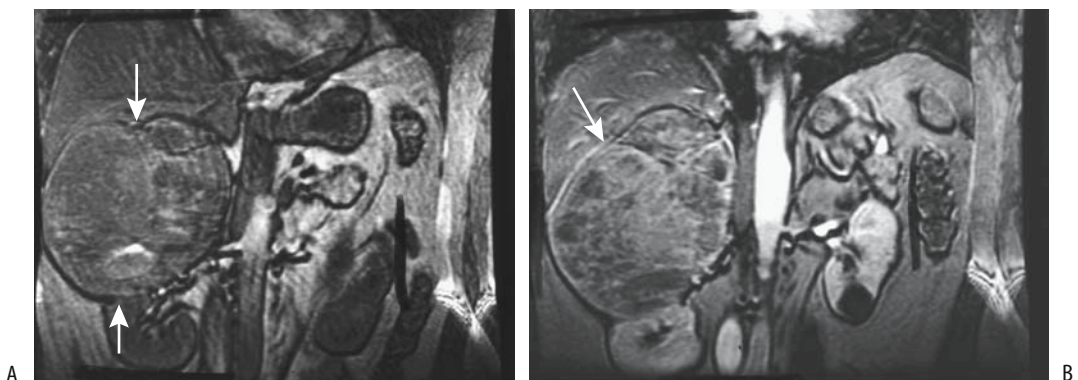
Adrenal carcinoma. Precontrast (A) and contrast-enhanced (B) magnetic resonance (MR) images reveal a large, heterogeneous right adrenal tumor (arrows). (Source: Burgener FA, Meyers SP, Tan RK, Zaunbauer W. *Differential Diagnosis in Magnetic Resonance Imaging*. Stuttgart: Thieme, 2002, with permission.)
